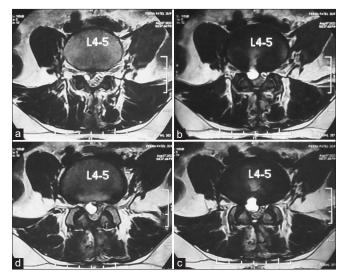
T2-weighted axial images at (a) L4 lower end plate; (b) upper discal margin; (c) mid-discal level; and (d) lower discal margin demonstrating the hyperintense lesion in the central and right paracentral location with direct communication to the intervertebral disc.
